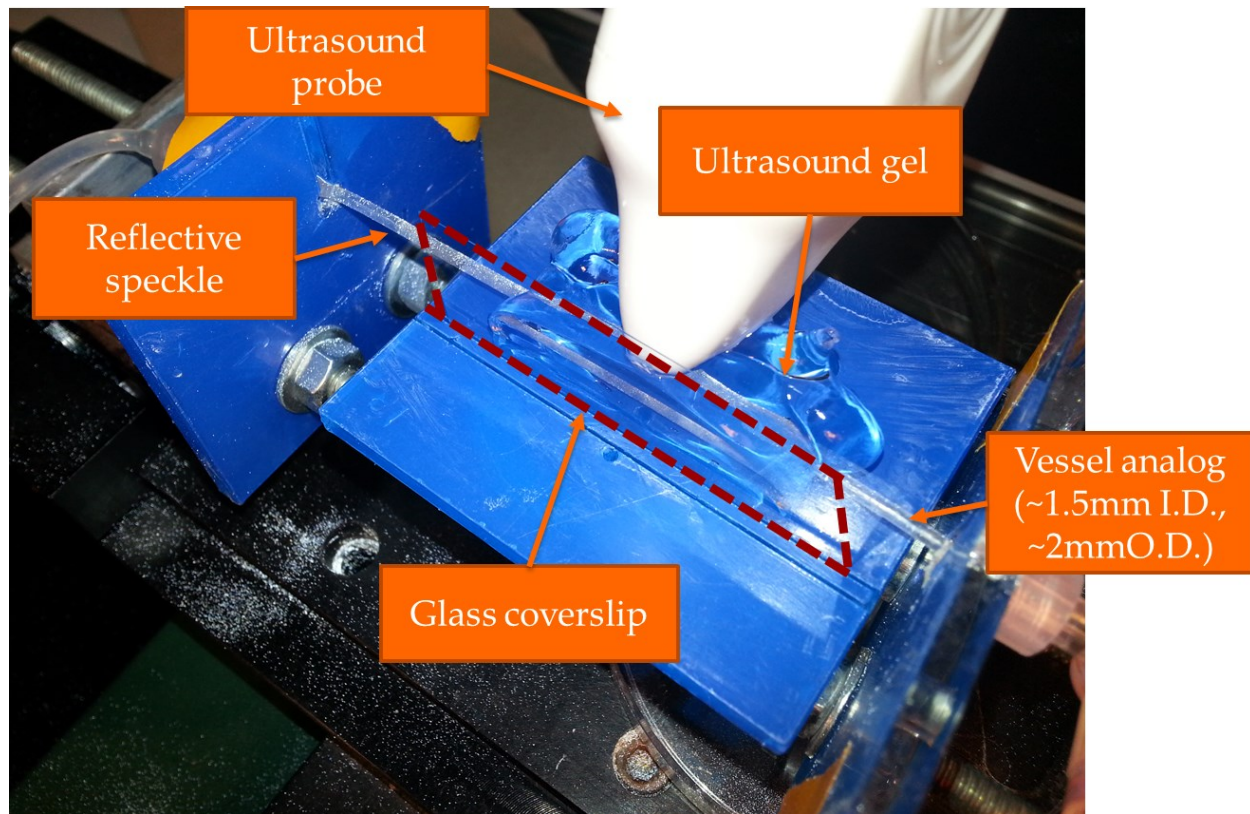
Close-up of ultrasound validation tubing setup. A large glass coverslip is used to create an optically flat surface behind which resides the ultrasound gel. This allows for clear, undistorted imaging of the tubing wall which has been pre-speckled to create a large light intensity distribution.
